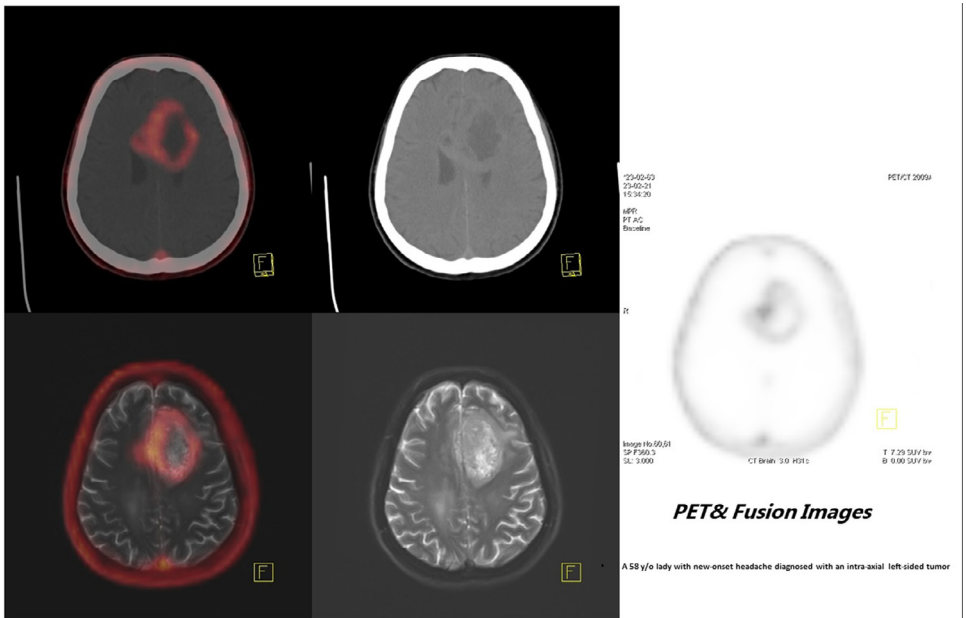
PET, CT, MRI and fusion of PET and CT/MR images of a 58 y/o woman with new-onset headache diagnosed with the left intra-axial para-falcine mass with extension to the contra-lateral hemisphere which is confirmed with High-grade glioma (WHO IV). Based on WHO classification 2016.
